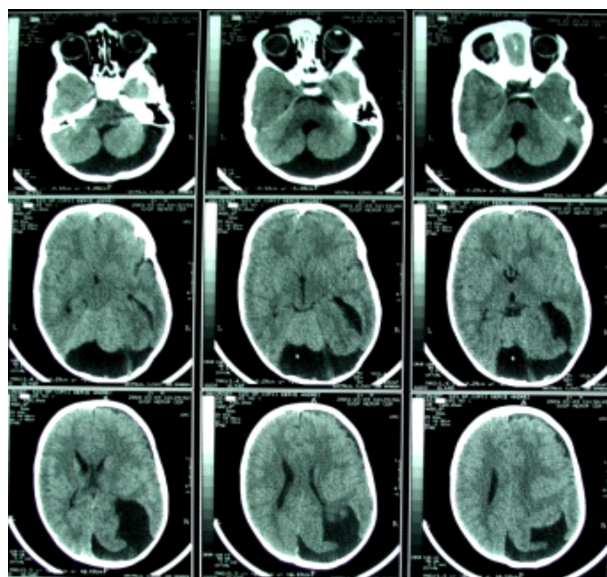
Dandy-Walker malformation. CT scan: hypodense formation with densities closes to those of CSF, which occupies approximately 1/2 of the posterior fossa and communicate with the posterior horn of the lateral right ventricle being much dilated; absence of the vermis; dilatation of the fourth ventricle.
